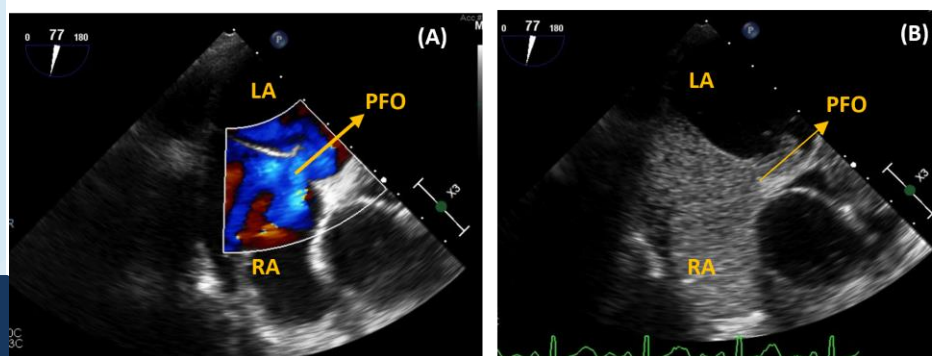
(A) Transesophageal Echocardiogram- colorflow doppler showing right to left shunting via PFO, (B) Transthoracic Echocardiogram with Positive bubble study significant for increased shunting on performing Valsalva maneuver.
